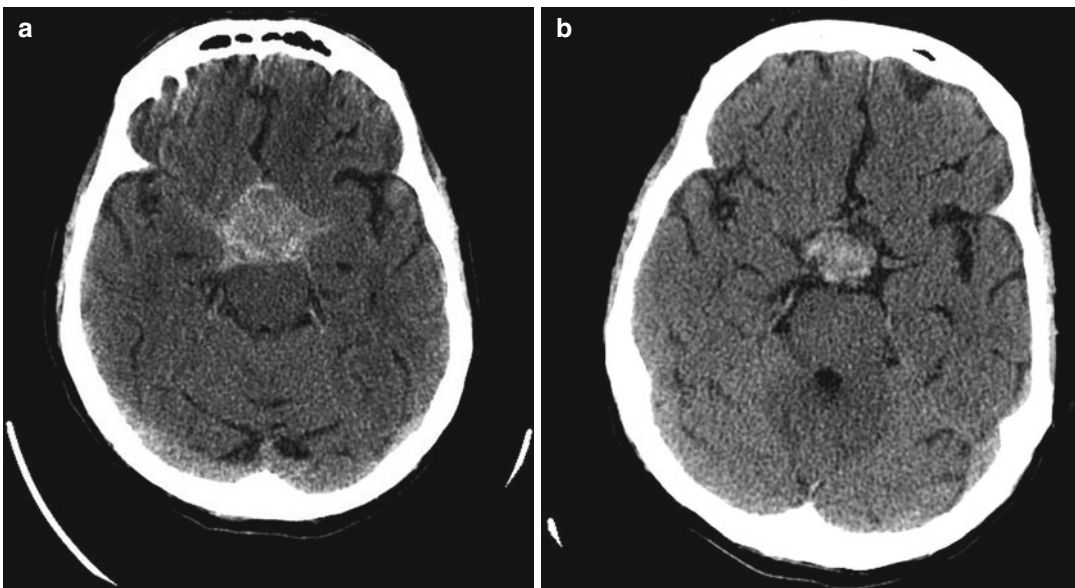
(a) CT scan shows hemorrhagic PA extending locally to the suprasellar cisterns. (b) Postoperative CT scan after pituitary removal
